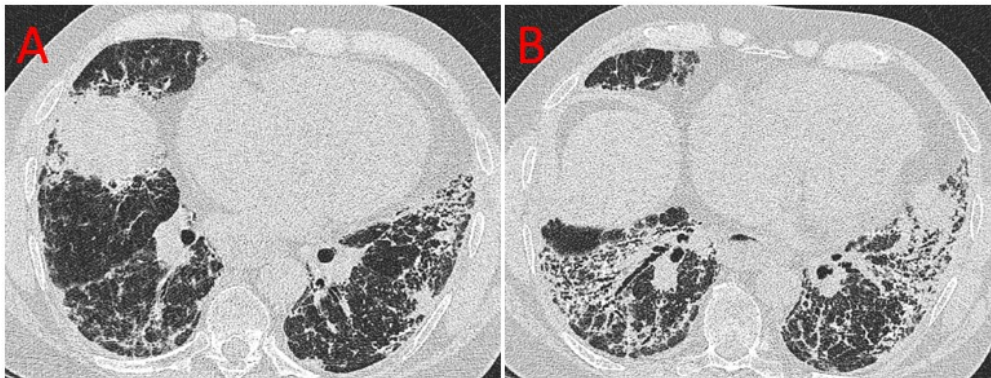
High resolution CT dicom's from the one patient with antisynthetase syndrome from the ILD-PH cohort.
